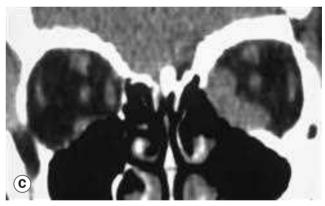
(A) Left idiopathic orbital inflammatory disease; (B) CT axial view showing ill-defined orbital opacification; (C) coronal view
